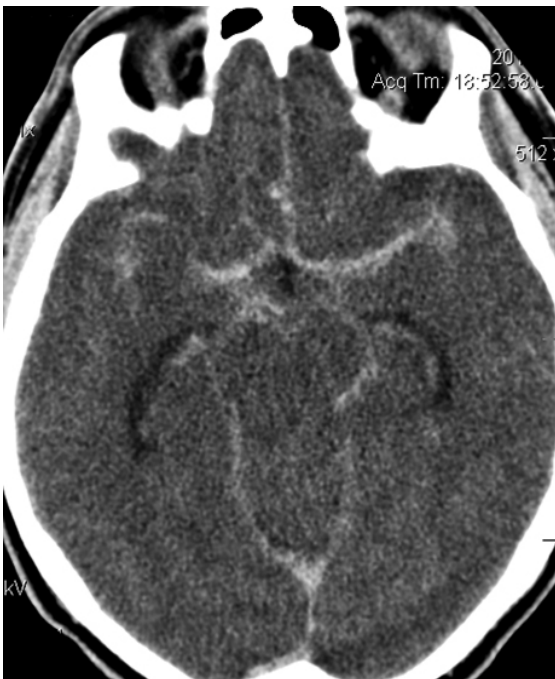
Axial CT scan of the brain showing subarachnoid hemorrhage
